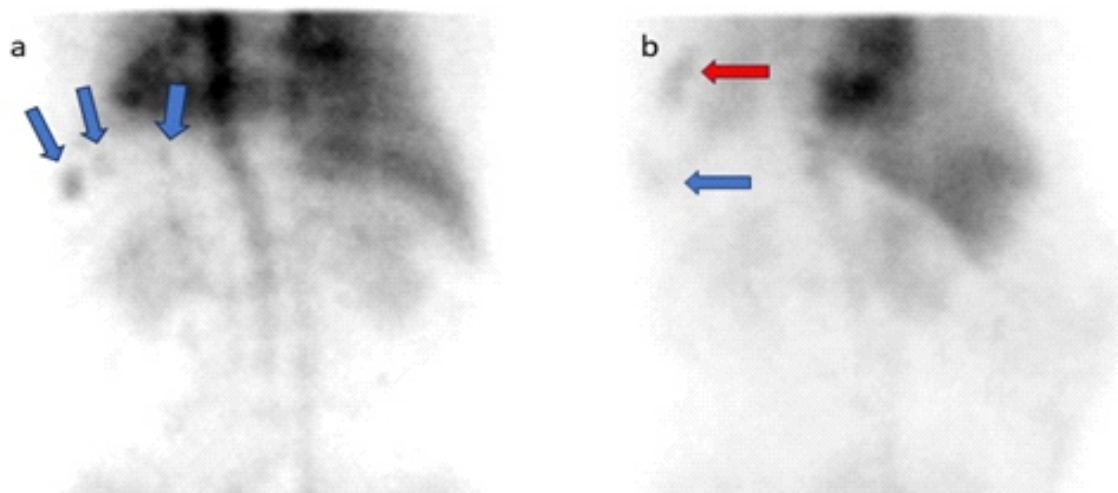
Selective spleen scintigraphy using heat-denatured erythrocyte-labeled technetium-99m: a) Posterior planar image shows focal activity uptake in three distinct foci within the splenic region (blue arrows). b) Lateral planar image reveals fusiform activity uptake extending vertically across 3-4 rib spaces beneath the pleura adjacent to the posterolateral segment of the left chest wall (red arrow) and focal activity uptake in the splenic region (blue arrow).
